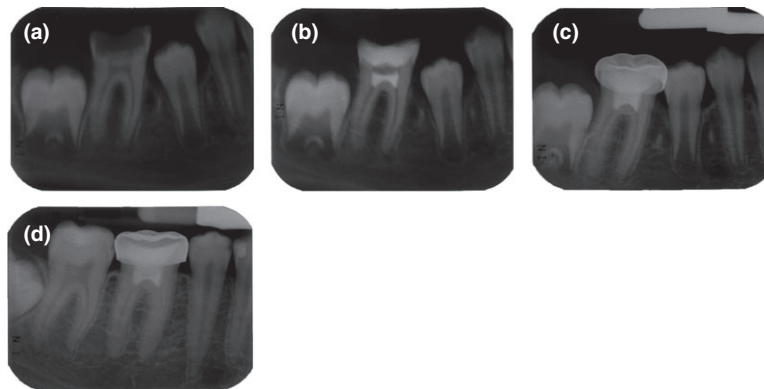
Radiographic evaluation of case 2 (a) preoperative radiograph demonstrating radiolucency around the mesial root of tooth 46, (b) immediately after MTA pulpotomy, (c) 6-month postoperative radiograph and (d) 5.5-year postoperative radiograph demonstrating PCO.
